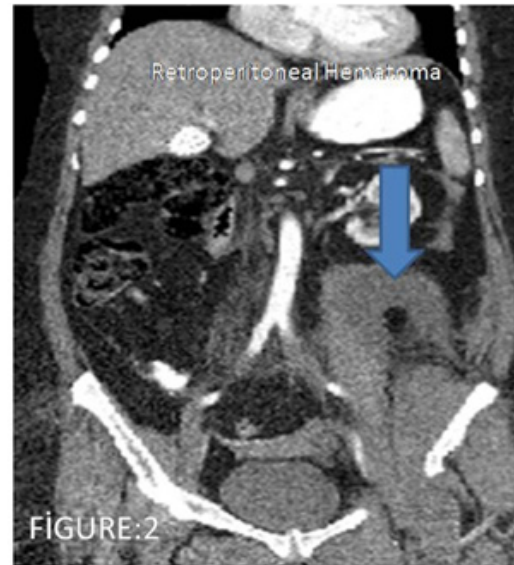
Monitoring with computed tomography of retroperitoneal hematoma
